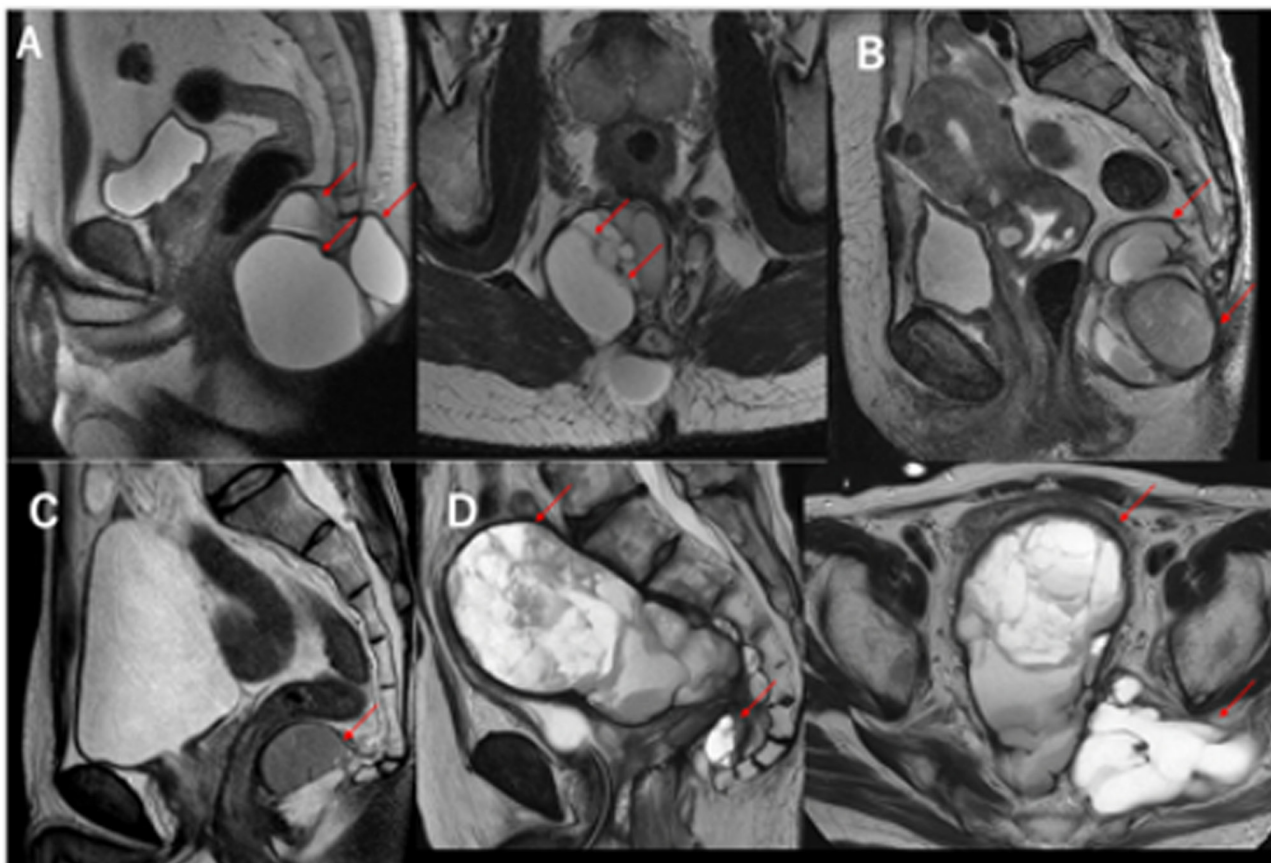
Magnetic resonance imaging of tailgut cysts. (A) Well-circumscribed multilocular lesion, hyperintense on T2WI, in the retrorectal space (Patient 1, arrows). (B) Cystic lesion accompanied by daughter cyst, hyperintense on T2WI (Patient 2, arrows). (C) Focal cystic lesion, hyperintense on T2WI (Patient 3, arrow). (D) Large cyst with numerous small septa with a mass with a solid component, hyperintense on T2WI, in the presacral space (Patient 4, arrows). T2WI, T2-weighted imaging.
